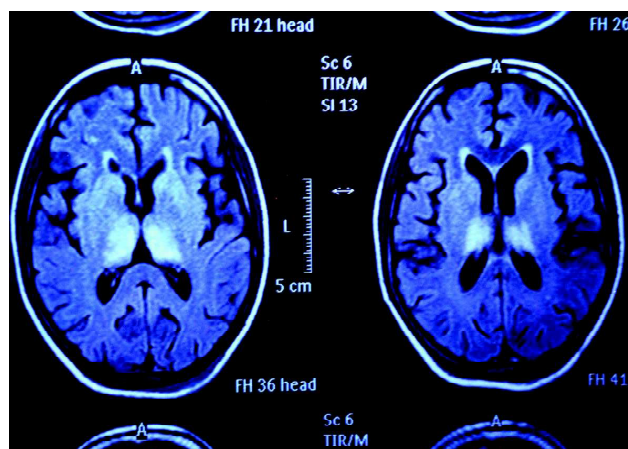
MRI showing bilateral thalamic hyperintensities on T2-W sequences suggestive of viral encephalitis.
